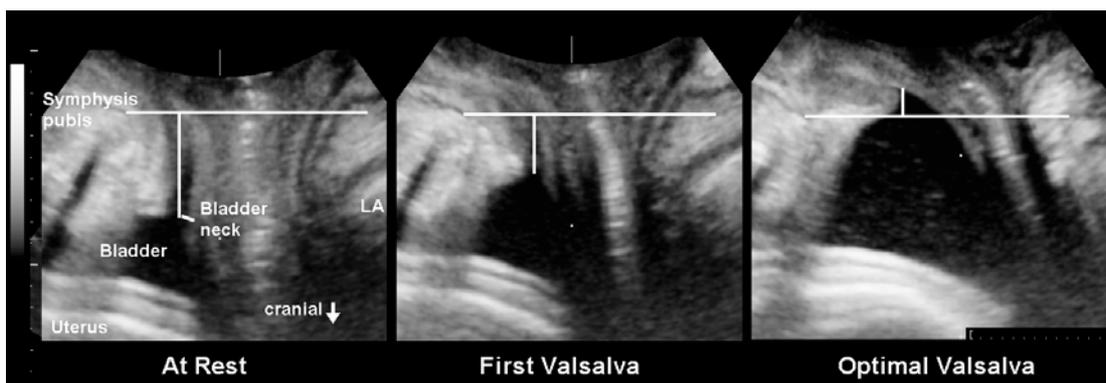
The effect of levator co-activation on bladder neck descent. Midsagittal views at rest (left), on first Valsalva, confounded by levator co-activation (central image) and on optimal Valsalva, after biofeedback teaching (right image). Translabial ultrasound, 8-4 MHz transducer. The horizontal line signifies the inferior margin of the symphysis pubis.
